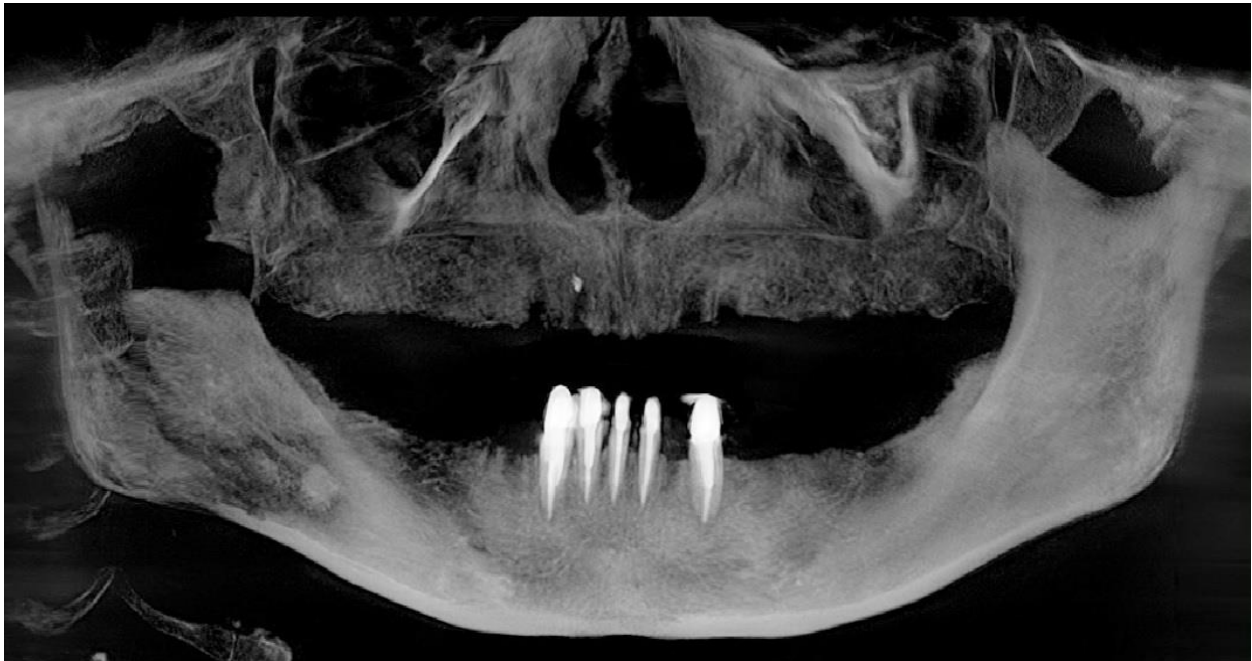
Preoperative panoramic X-ray showing maxillary and posterior bilateral edentulism.
